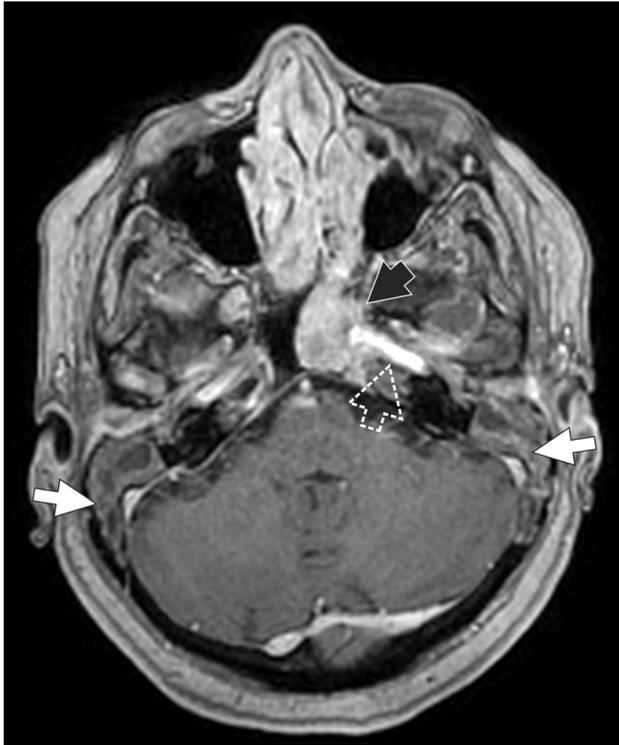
Magnetic resonance imaging of the brain, axial section, T1-weighted sequence after gadolinium administration, case number four. A large lesion centered at the left cavernous sinus (black arrow) surrounding the left internal carotid artery (dotted arrow), and extending to the sphenoid sinus, measuring $2.4 \times 2.1 \times 2.5$ cm. Bilateral complete obliteration of mastoid cells (white arrows).
